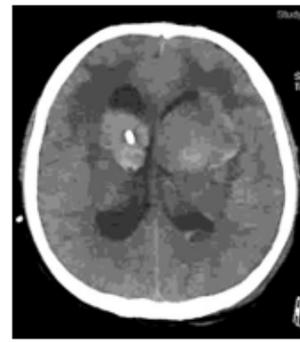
Head computed tomography (CT), hemorrhage findings in basal ganglia.
